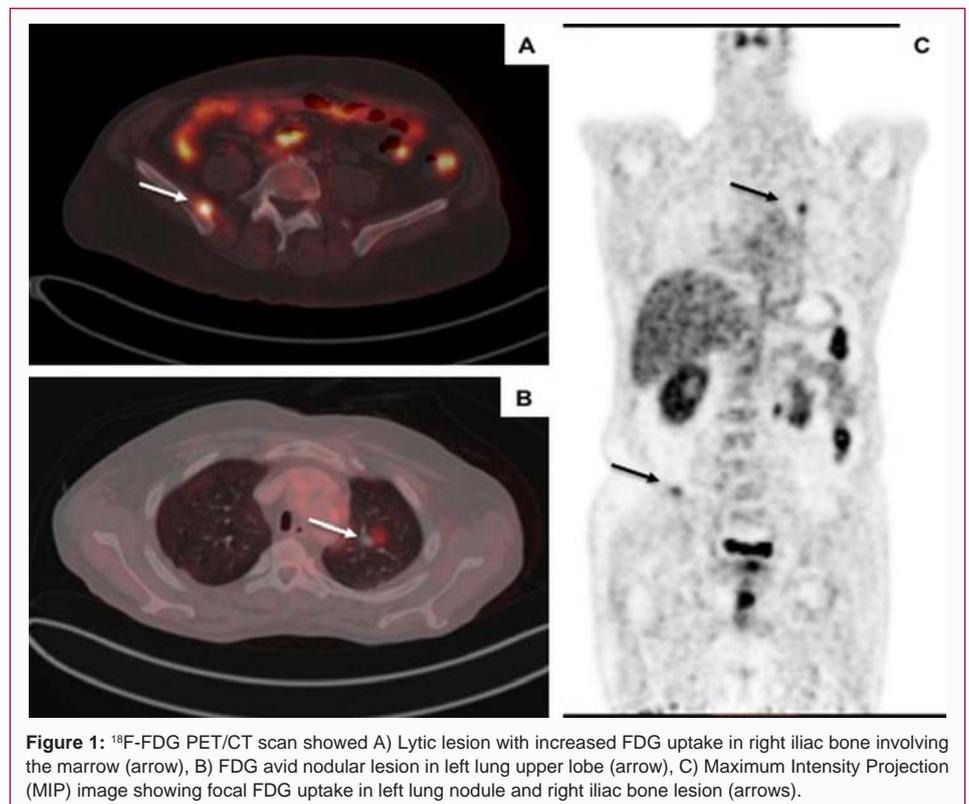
¹⁸F-FDG PET/CT scan showed A) Lytic lesion with increased FDG uptake in right iliac bone involving the marrow (arrow), B) FDG avid nodular lesion in left lung upper lobe (arrow), C) Maximum Intensity Projection (MIP) image showing focal FDG uptake in left lung nodule and right iliac bone lesion (arrows).
